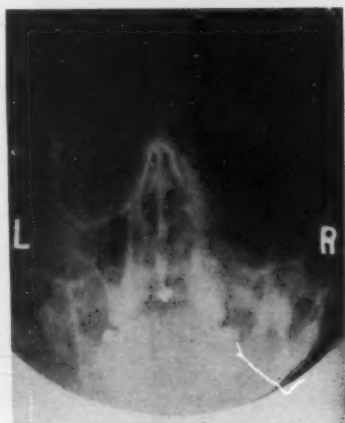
X-ray after operation.
